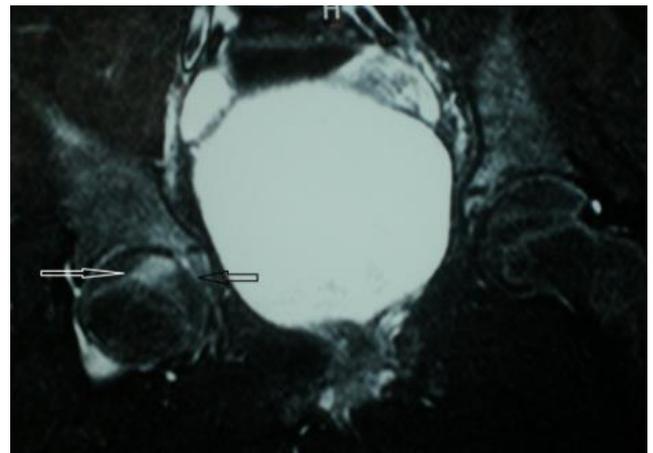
Coronal MRI STIR image demonstrating bone marrow oedema in the femoral head (white arrow) and in the acetabulum (black arrow)
